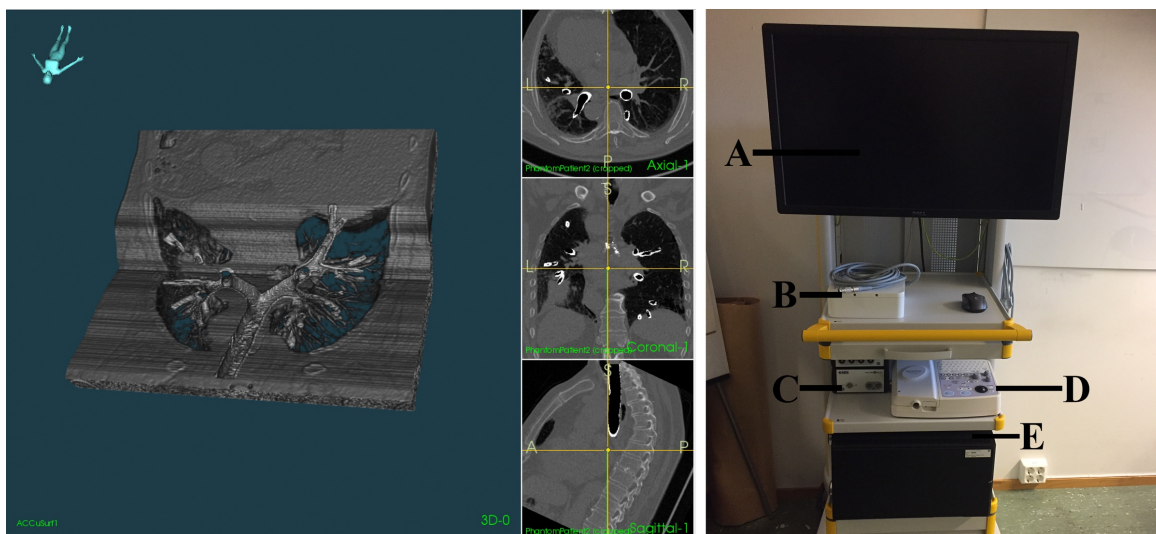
Left: Layout organised 3D+ACS View, ACCuSurf and ACS of fused silicon CT data and patient thorax CT. Right: CustusX rack; A) monitor, B) electromagnetic field generator, C) inlets for tool sensors, D) keyboard for ultrasound probe, E) Computer hardware.
